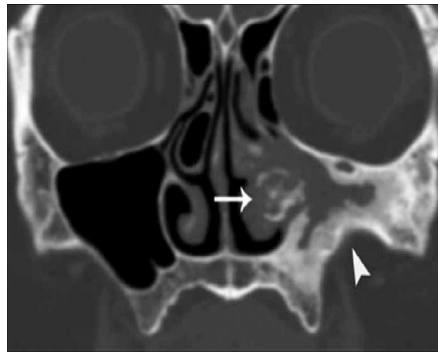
On noncontrast coronal CT image of the paranasal sinuses, there is complete opacification of the atelectatic left maxillary sinus, with associated thickened walls, which is consistent with chronic fungus sinusitis . There is a coarse nodular calcification replacing the left inferior turbinate, representing a fungus ball (arrow). (CT Image provided by prof. Mahmud Mossa-Basha .The many faces of fungal disease of the paranasal sinuses: CT and MRI findings Interv Radiol 2013; 19:195–200)
